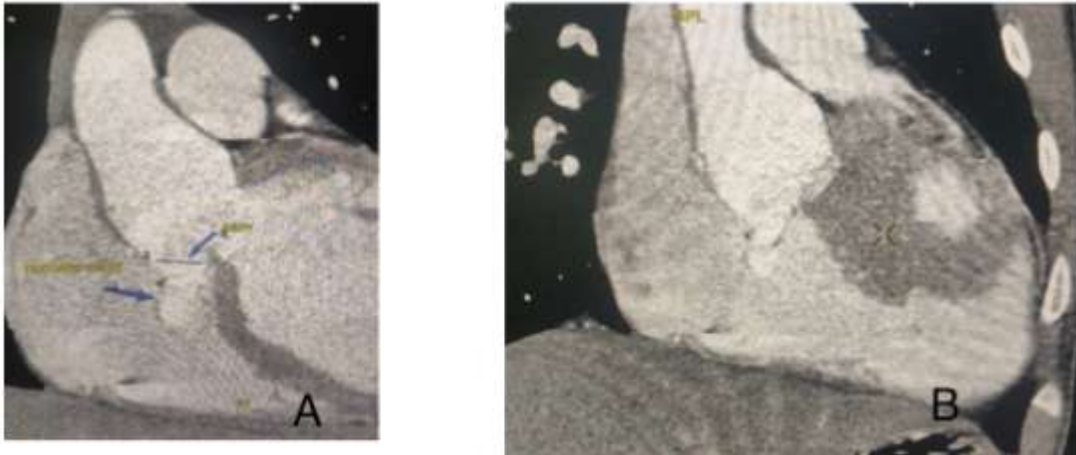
14-month-old male child with chest complaints. Oblique post-contrast cardiac CT revealing a fistulous tract originating from the aortic sinus, opening into the right ventricle just below the tricuspid valve, indicative of a ruptured sinus of Valsalva.
